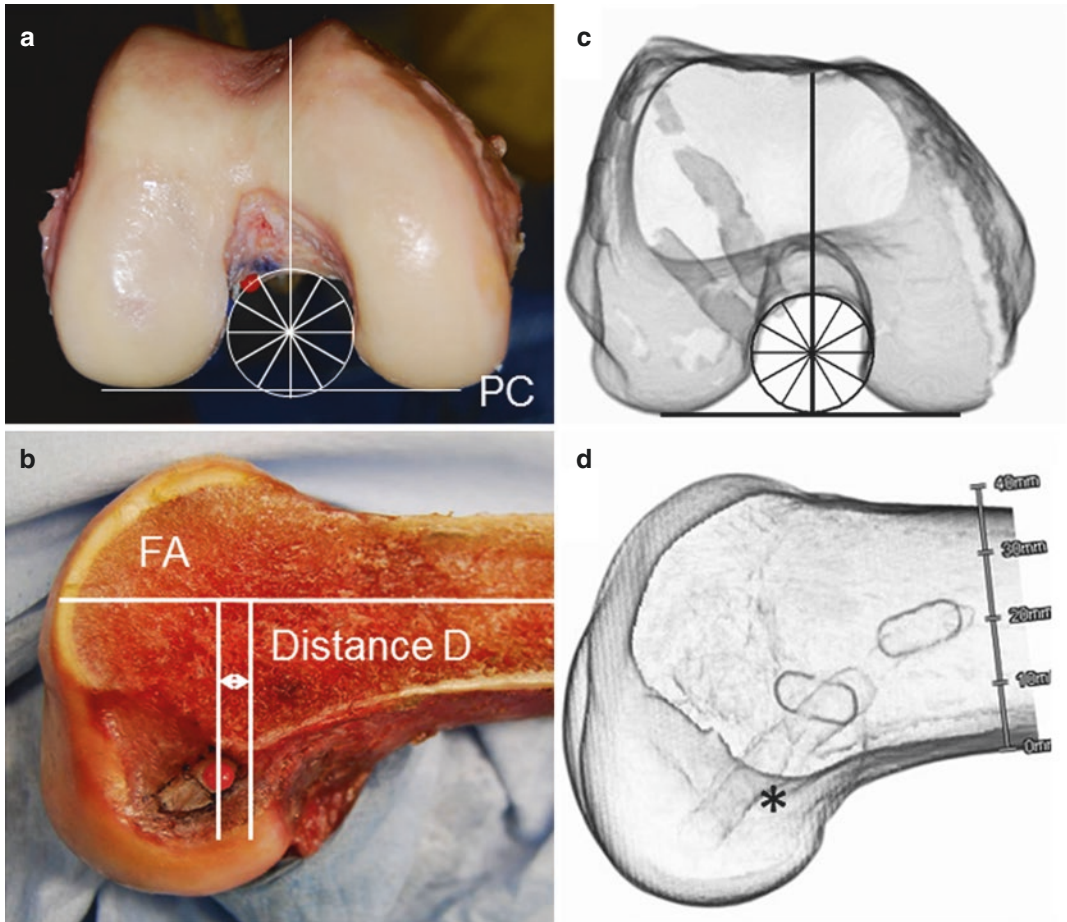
On a photograph taken in the axial view (a), the center of the AM bundle attachment (a red marker) was measured with the so-called “clock” system. On a photograph taken in the lateral view (b), we measured “Distance D” from the POIN. Three-dimensional CT images taken
